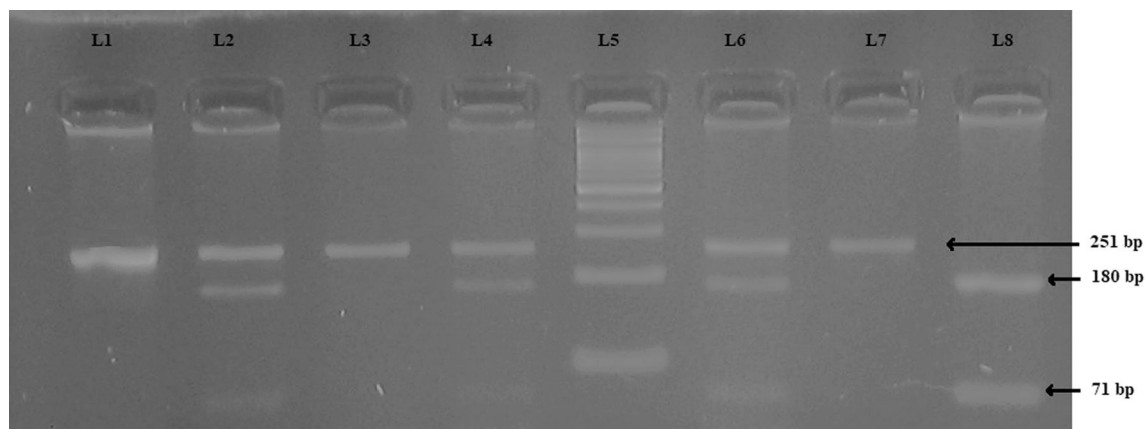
The 4% agarose gel picture of *BbsI* digested products of *TNF-α* rs1799964 gene. Lane 1 shows undigested PCR product corresponding to a band of 264 bp; lanes 2, 4 and 6 show CT genotype corresponding to three bands size of 251 bp, 180 bp and 71 bp; lanes 3 and 7 show the CC genotype corresponding to one bands of 251 bp, whereas lane 8 shows TT genotype corresponding to two band of 180 bp and 71 bp and lane 5 shows 100 bp ladder
